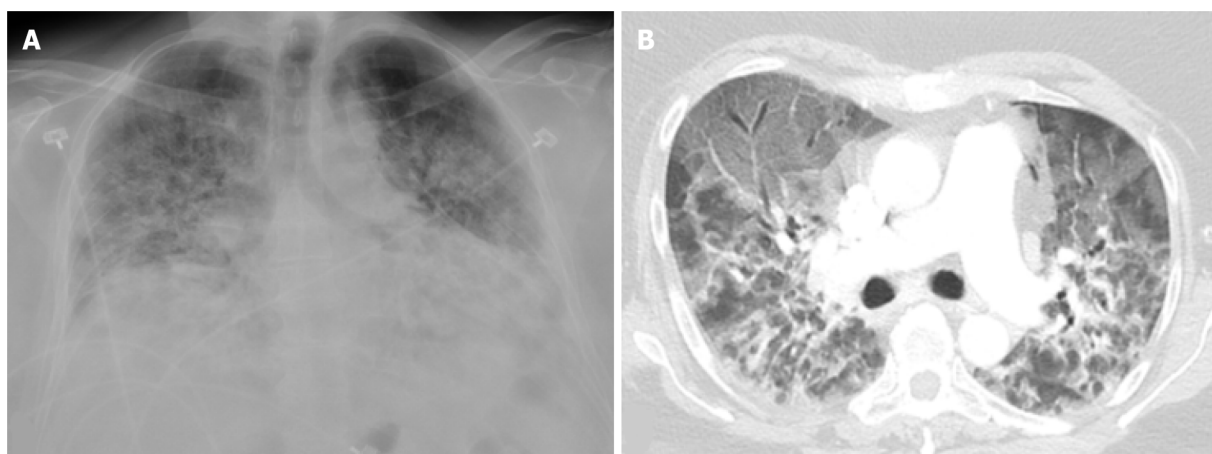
Severe coronavirus disease 2019 pneumonia. Portable chest X-ray and axial image from a computed tomography of the chest in a 52-yr-old female with a history of morbid obesity who was admitted for acute hypoxic respiratory failure secondary to severe acute respiratory syndrome coronavirus 2. A: Chest X-ray shows low lung volumes with diffuse bilateral alveolar and interstitial opacities; B: Chest computed tomography shows diffuse ground glass opacities anteriorly, typical of acute lung injury. The peribronchial and perilobular opacities posteriorly are typical of acute lung injury that has entered a healing phase. The patient subsequently expired.
